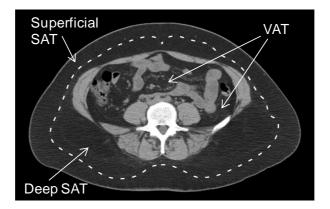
A computed tomography scan depicting the superficial and deep subcutaneous adipose tissue (SAT) and visceral adipose tissue (VAT) depots. The broken line represents Scarpa's fascia<sup>23</sup>.
